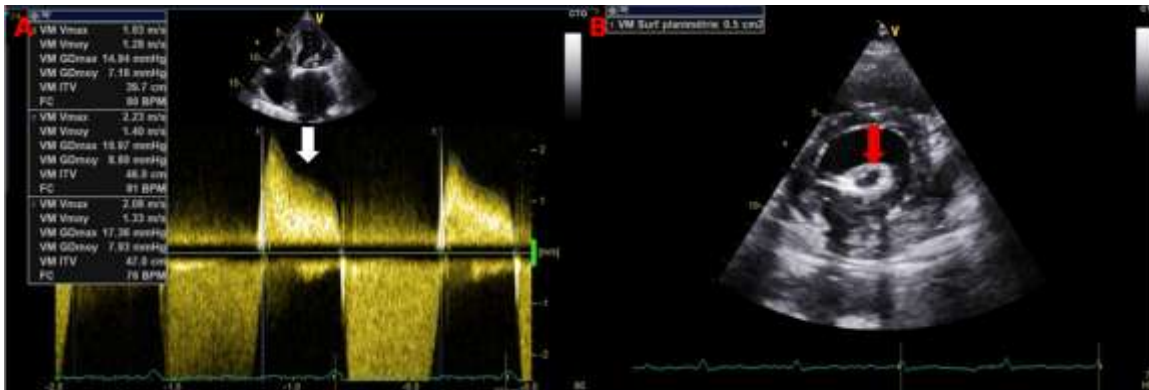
Transthoracic echocardiography demonstrating severe rheumatic mitral restenosis and Doppler hemodynamic assessment.
